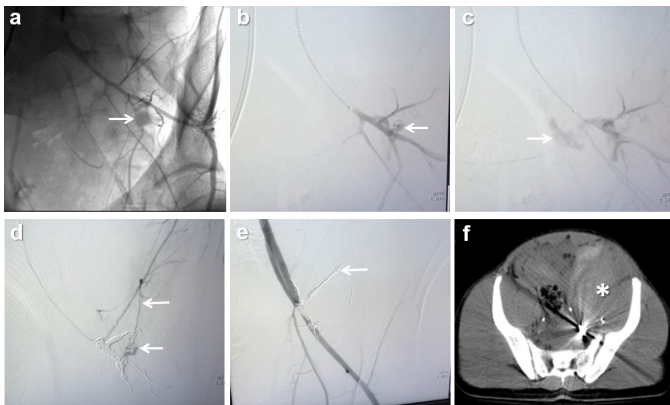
Digital subtraction angiography (DSA) and computed tomography (CT) images of a hemodynamically unstable 18-year-old male patient with a pelvic fracture and massive abdominal bleeding due to a fall from a height. Diagnostic DSA images (a, b, and c) show active extravasation (arrows) in arteries originating from the posterior sector of the left internal iliac artery. After coil transarterial embolization, DSA image (d) shows retrograde filling from a different artery (arrows) and superselective complete embolization (e). Pelvic CT image (f) shows a massive hematoma (asterisk).
